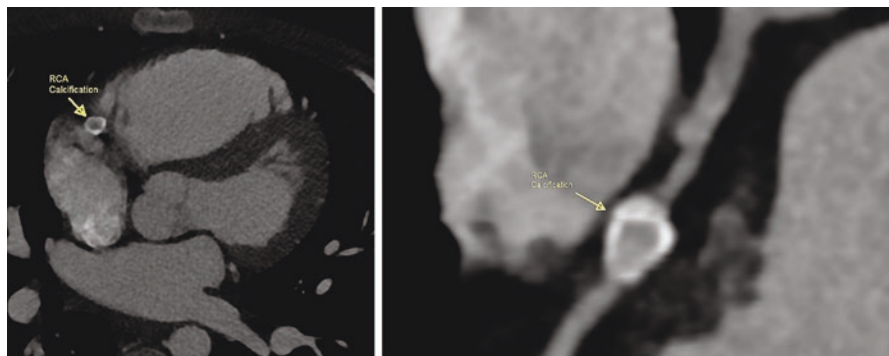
Follow-up cardiac CT in patient with Kawasaki disease presenting with areas of calcification within the aneurysm of the right coronary artery
